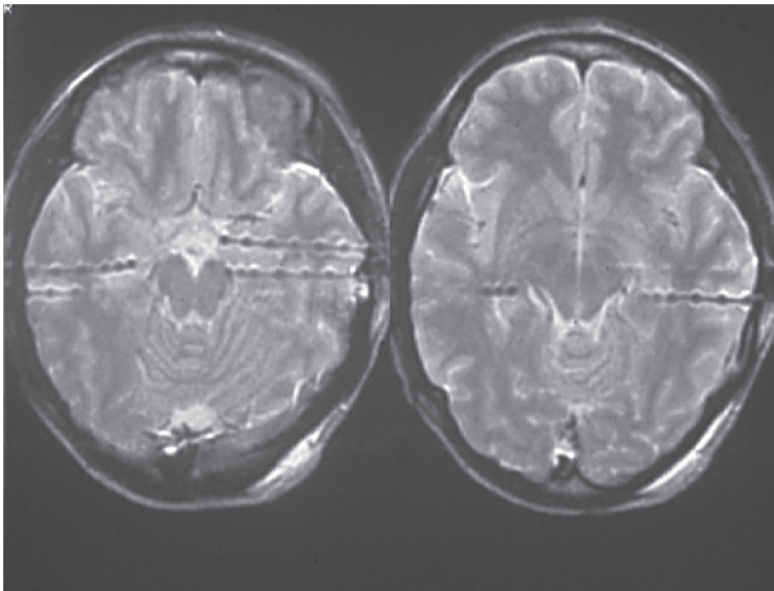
(a) Vertical parasagittal hemispherotomy. (a) Coronal plane demonstrating the cortical parasagittal window to the lateral ventricle (1), followed by the posterior callosotomy (2), which will be pursued towards the splenium. The vertical black bar towards the temporal horn represents the laterothalamic incision. (b) Following resection of the ipsilateral splenium (2), the floor of the ventricular trigone (3) will be sectioned, thus interrupting the fonicial fibres. The laterothalamic incision is then performed (4, 5). Following anterior completion of the callosotomy, the posterior part of the gyrus rectus is resected (6) and, from here, the dissection line is guided laterally across the frontal horn and the caudate nucleus (8), thus completing the disconnection of the entire hemisphere. (c) Postoperative axial MRI in a patient with Rasmussen's encephalitis, demonstrating the line of the laterothalamic disconnection. Figures reproduced with permission from Delalande O, Bulteau C, Dellatolas G *et al.* Vertical parasagittal hemispherotomy: surgical procedures and clinical long-term outcomes in a population of 83 children. *Neurosurgery* 2007; 60(ONS Suppl. 1): ONS1–ONS32.
